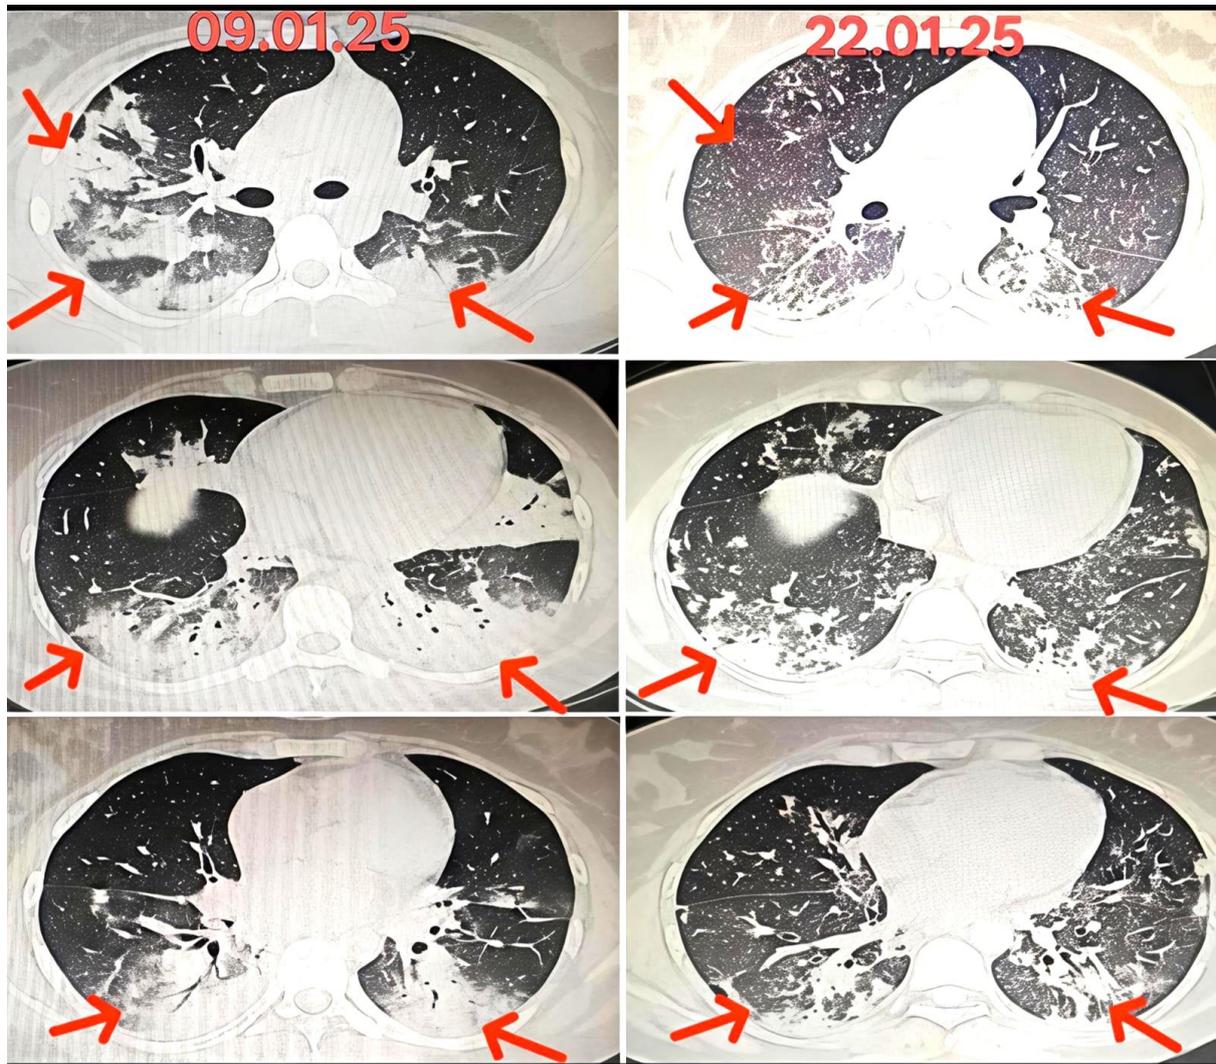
HRCT Chest (09.01.25 and 22.01.25)
